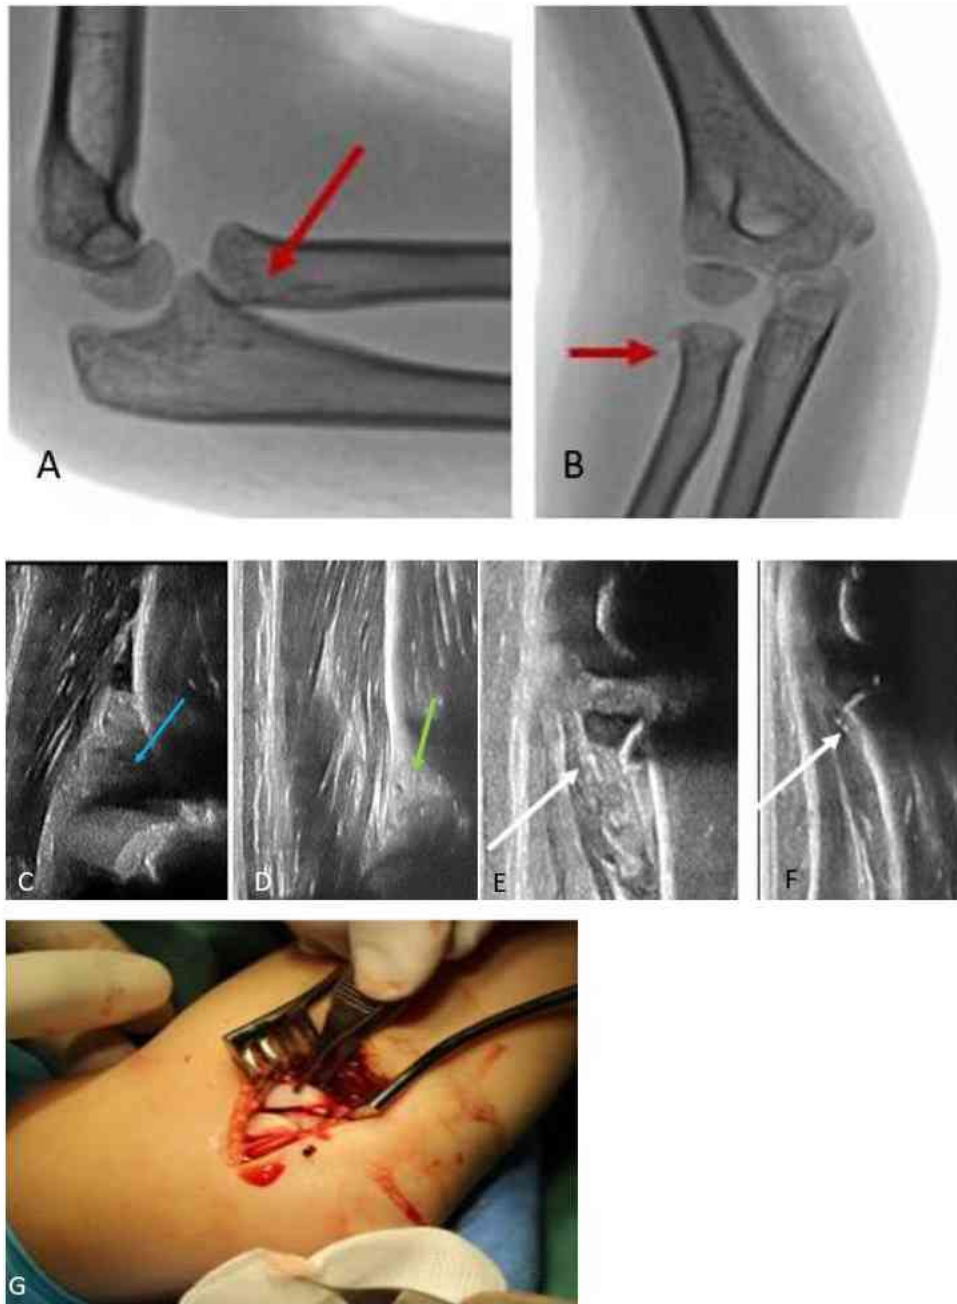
Intraarticular radial head fracture with subtle X-ray findings
